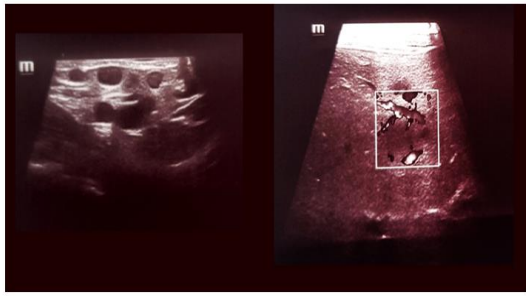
Ultrasound images showing well-defined hypoechoic nodules in the spleen (left) and liver (right)
